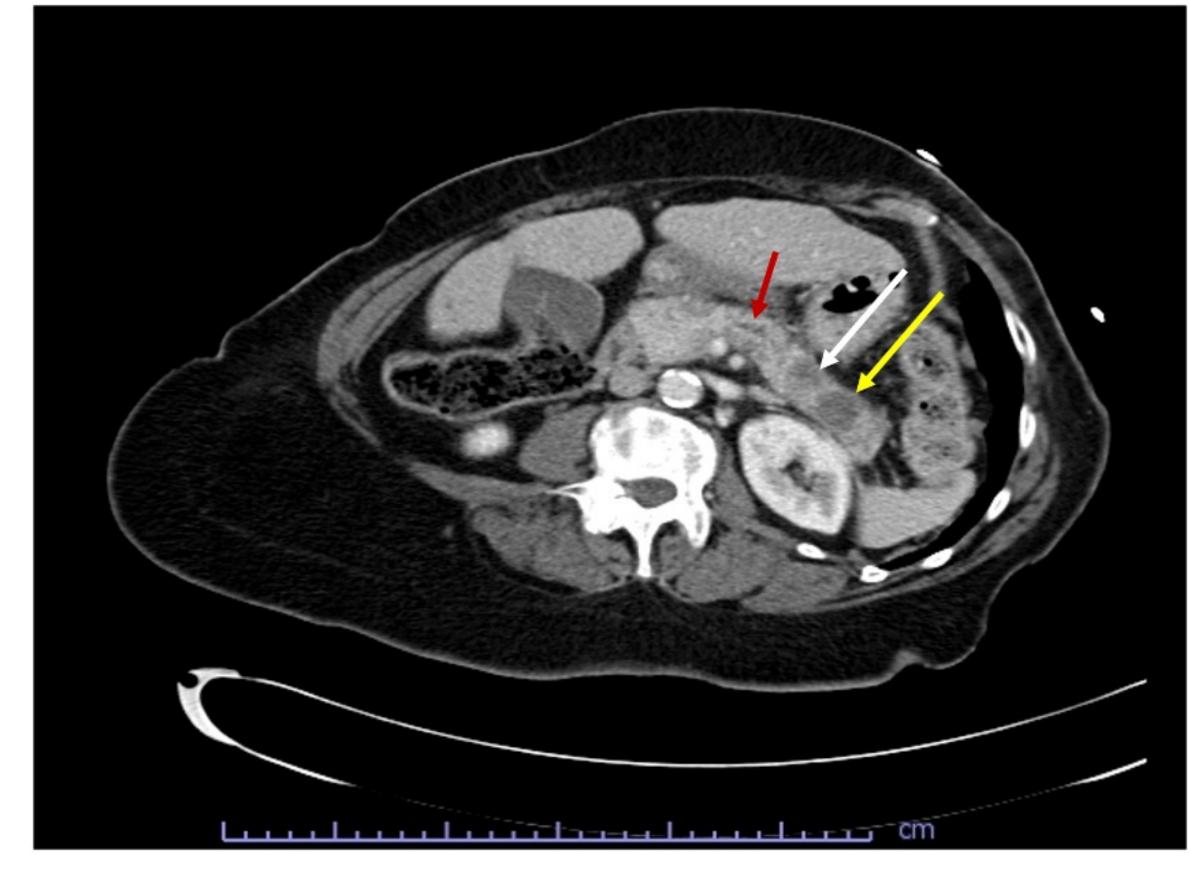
Axial-oblique abdominal-pelvic CT demonstrates a low-density lesion in the pancreatic tail (yellow arrow) measuring $2.3 \times 1.6 \text{ cm}$. An adjacent ill-defined low-density lesion (white arrow) measures $1.6 \times 1.0 \text{ cm}$. The pancreas is borderline in size, and the pancreatic duct is prominent (red arrow).
